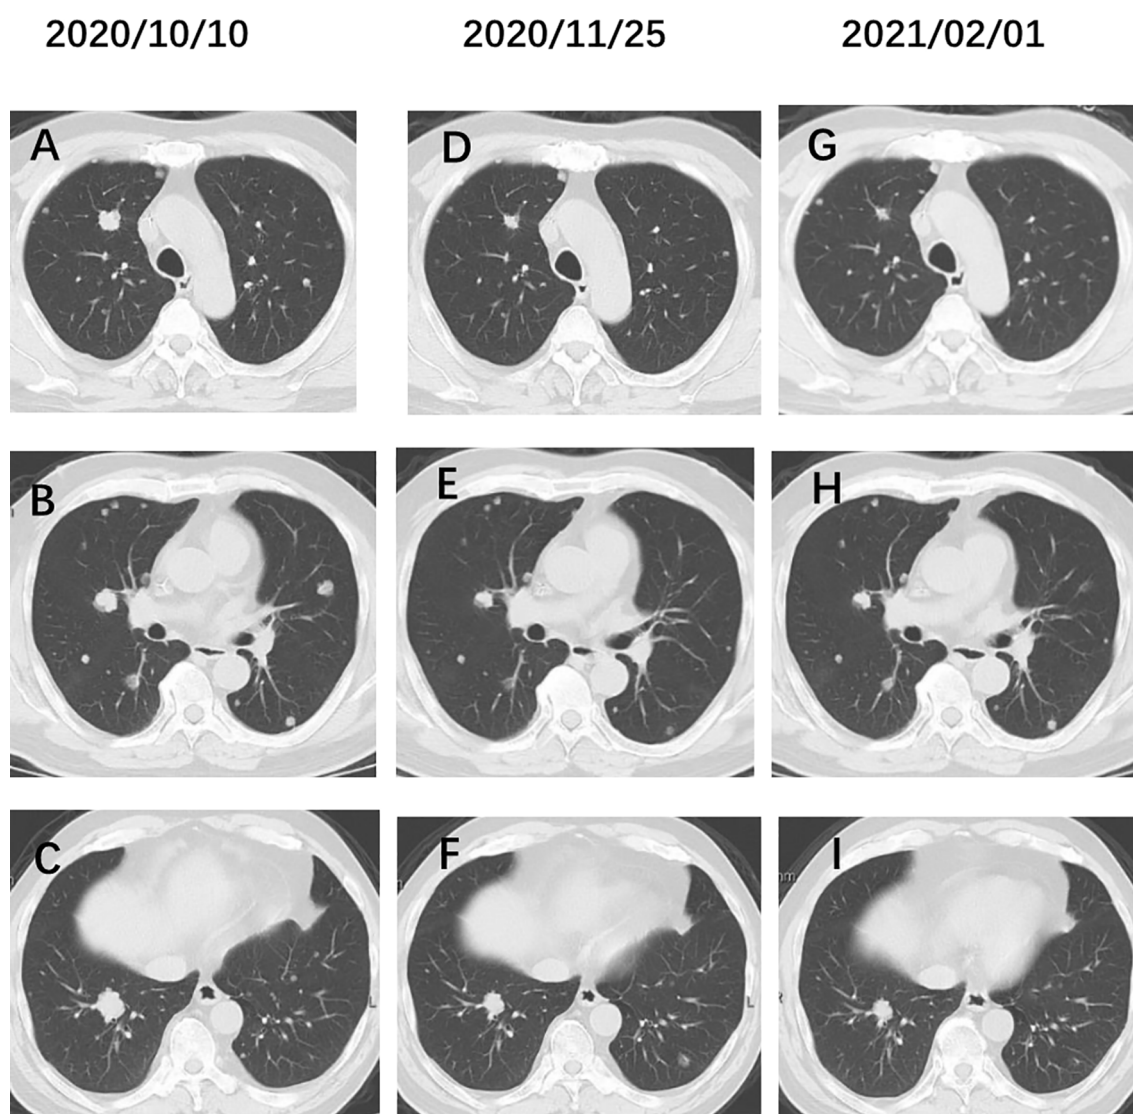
(A–C) Chest CT before administration of Irinotecan. (D–F) Chest CT after 3 cycles Irinotecan and bevacizumab therapy. (G–I) After 6 cycles Irinotecan and bevacizumab therapy. The pulmonary metastatic lesions were reduced by 50%.
